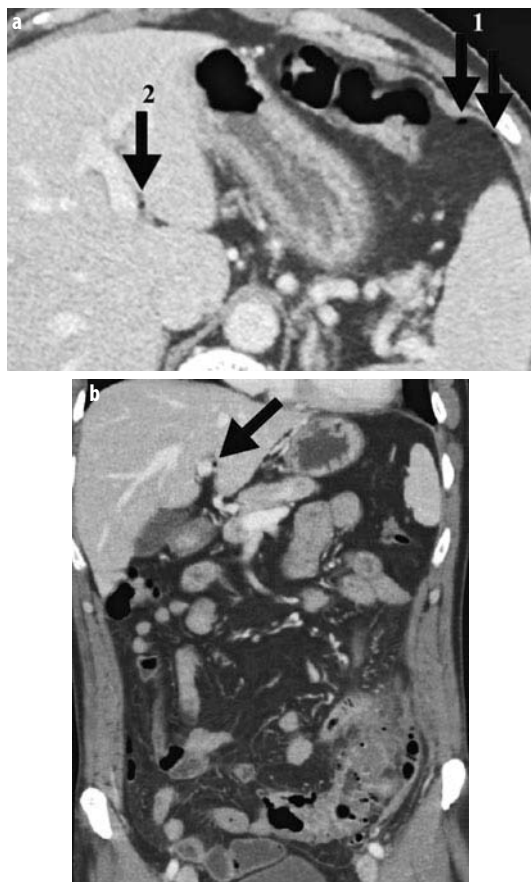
a, b. Perforated sigmoid diverticulitis. a CT demonstrates tiny bubbles of extraluminal gas within the left subphrenic space (arrows, 1) and hepatic pedicle (arrow, 2). The determination of a pneumoperitoneum from the perforated sigmoid diverticulitis (b) requires dedicated window settings. b Coronal reformat shows the patterns indicating the severity of the local extent of this case of sigmoid diverticulitis: thickened bowel wall with diverticula associated with dramatic changes of the pericolic fat and thickened root of the sigmoid mesocolon. Note the tiny bubble of extraluminal gas (arrow) within the hepatic pedicle
